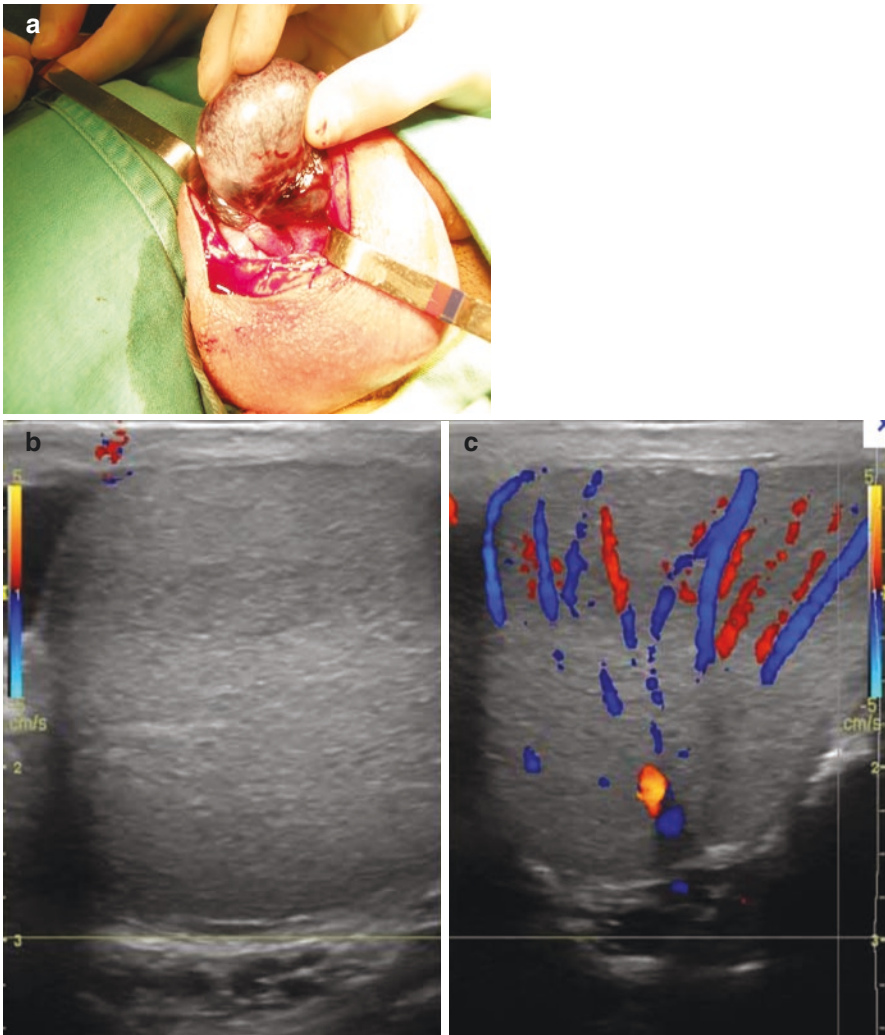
Testicular torsion. Testicular torsion is intravaginal (within the tunica vaginalis) in adolescent patients and is related to the “bell clapper” deformity. (a) Ischemic testicle with torsion of the spermatic cord. (b) Doppler images confirming no blood flow to the right testicle (b), with normal flow to the left testicle (c)
